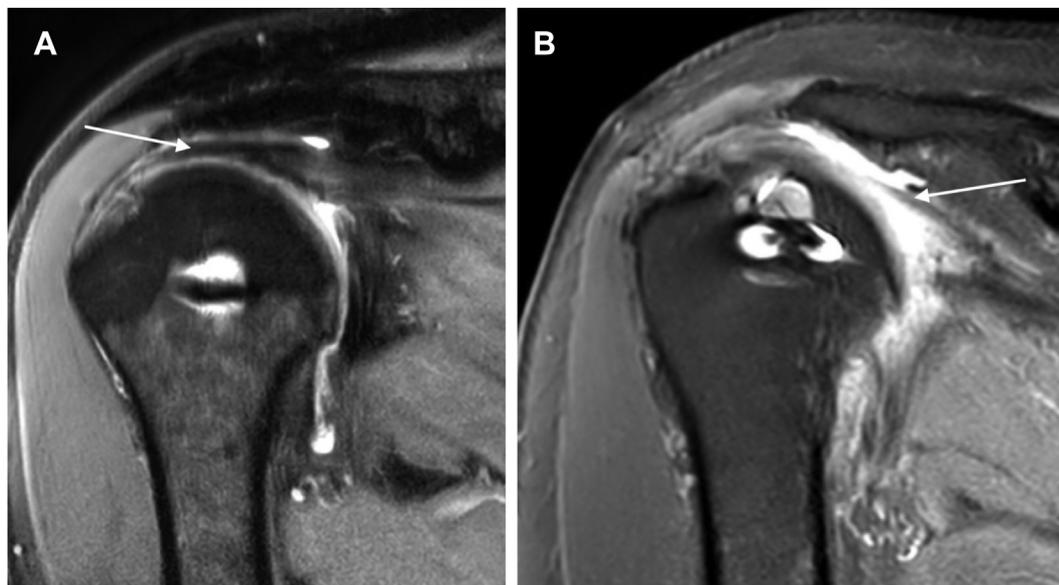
Postoperative magnetic resonance imaging scans used to measure Sugaya scale, showing scores of 2 (A) and 5 (B). The arrows point toward the upper part of the infraspinatus tendon.
